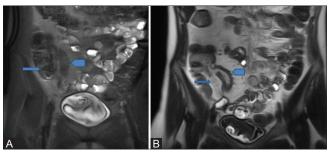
(A and B): (A) Coronal T2-weighted single-shot fast spin-echo images of the abdomen showing inadequately distended small bowel with collapsed terminal ileum (arrow head) and collapsed cecum (arrow). (B) Coronal T2-weighted single-shot fast spin-echo image of the abdomen obtained 15 min after (A) showing oral contrast opacifying a distended terminal ileum which shows loss of normal fold pattern (arrowhead) and contrast seen within the right colon and cecum (arrow)
